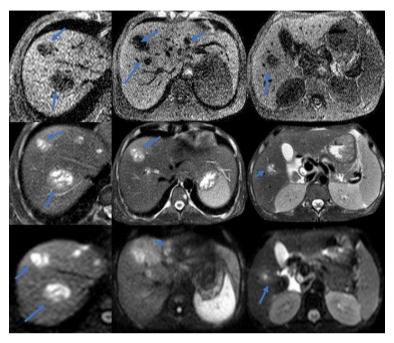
(A-I). MRI reveal multiple irregular abscesses of varying size in both lobes of liver, which appear hypointense on axial T1W(A-C), hyperintense on axial T2W(D-F) with restricted diffusion on diffusion weighted imaging (G-I) with filling defects (round worms) within the abscesses
